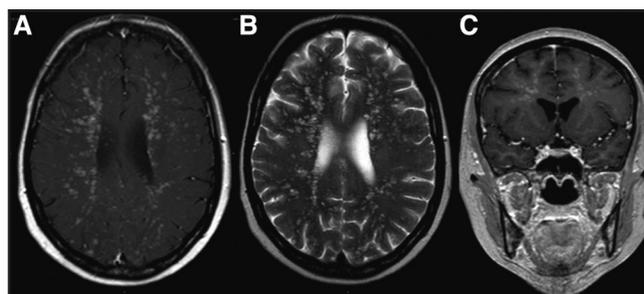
Brain MRI. Transverse T2-weighted images (A) and transverse (B) and coronal (C) contrast enhanced T1-weighted images show numerous punctiform hyperintense lesions at T2-weighted imaging, with enhancement after administration of gadolinium. The lesions follow a more or less curved pattern, consistent with perivascular distribution, without lesions at the gray-white matter interface.
